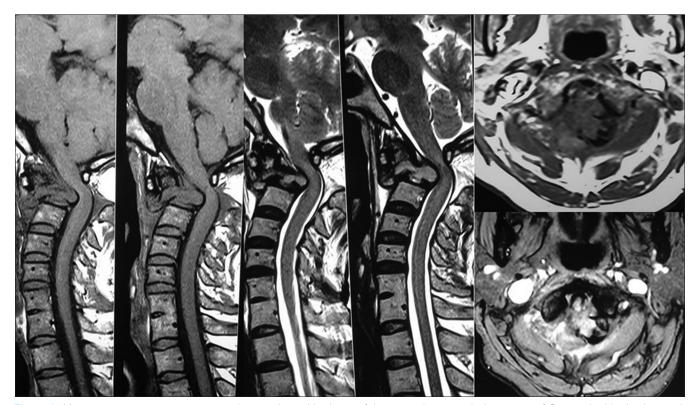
Magnetic resonance imaging cervical spine showed kyphosis of the cervical spine with destruction of C2 vertebral body along with posterior displacement of the severely compressed spinal cord
